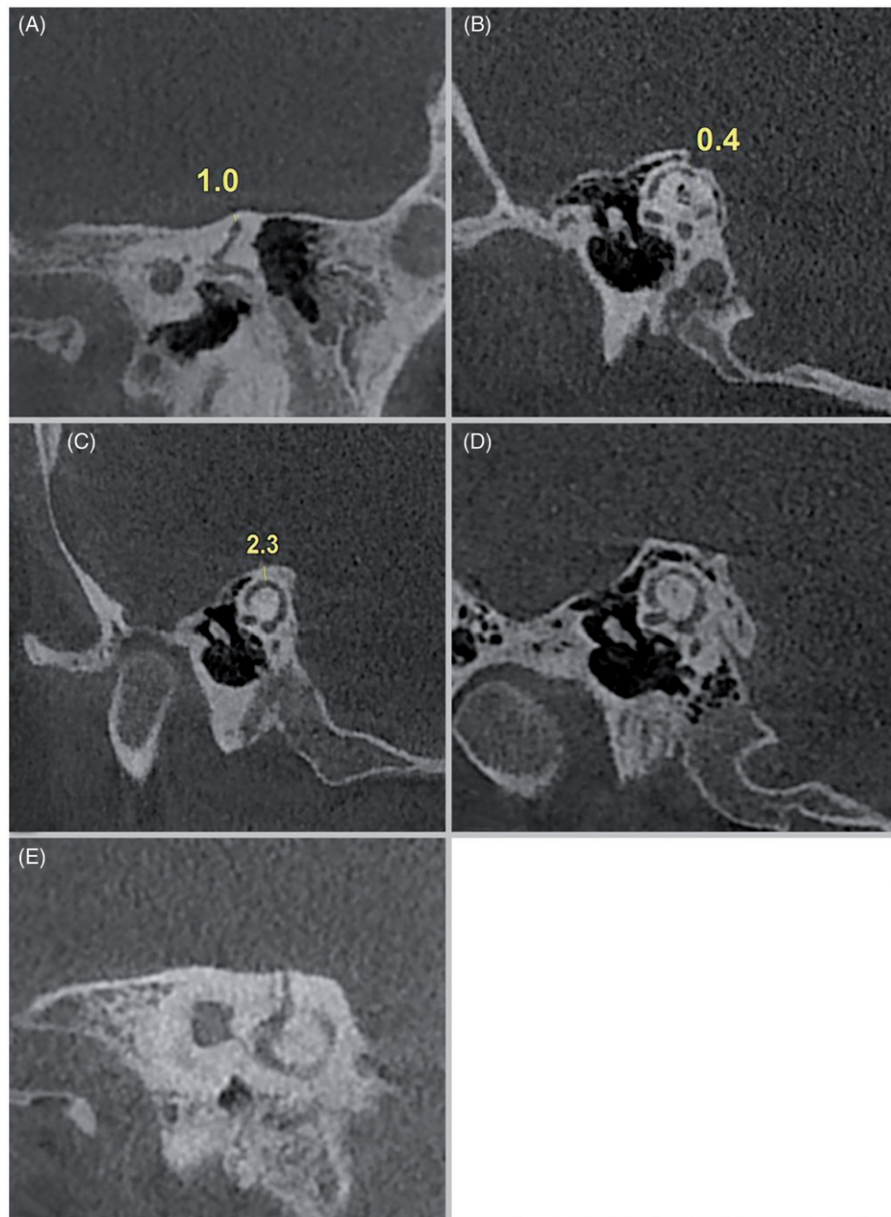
Cone beam computed tomography images show different radiologic features of the superior semicircular canal. (A) Normal. (B) Papyraceous. (C) Thick. (D) Pneumatized. (E) Dehiscent.
